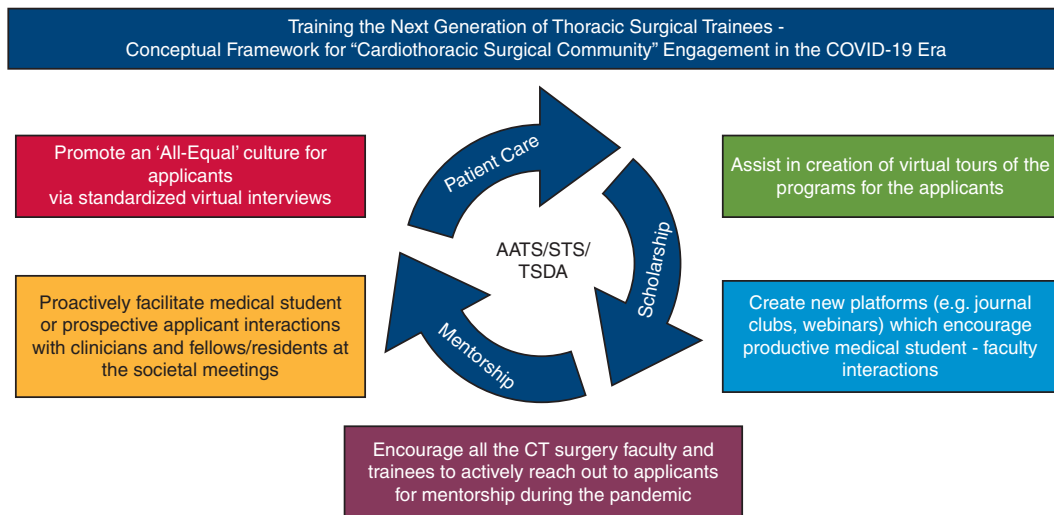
Conceptual framework for “Cardiothoracic Surgical Community” engagement in the COVID-19 era. *COVID-19*, Coronavirus disease 2019; *AATS*, American Association for Thoracic Surgery; *STS*, Society of Thoracic Surgeons; *TSDA*, Thoracic Surgery Directors Association; *CT*, cardiothoracic.
